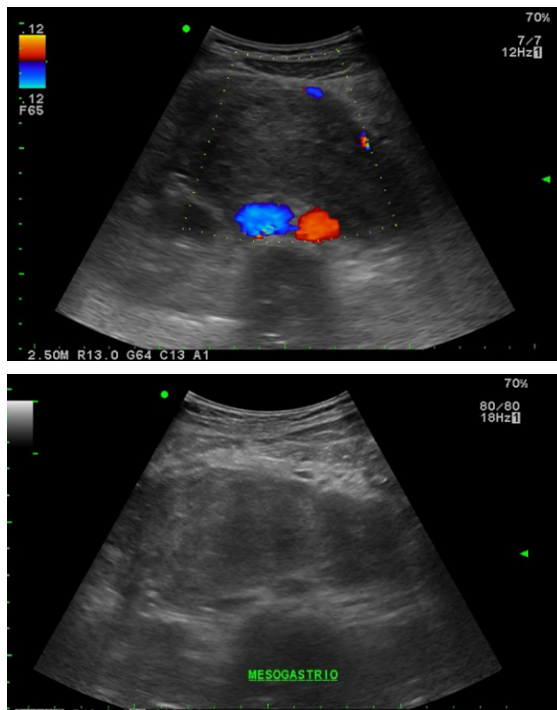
FAST ultrasound. Smooth-bordered, retroperitoneal, paravertebral, heterogeneous, avascular mass ($9 \times 5.7 \times 7.6$ cm; volume 214 cc) displacing adjacent structures.
